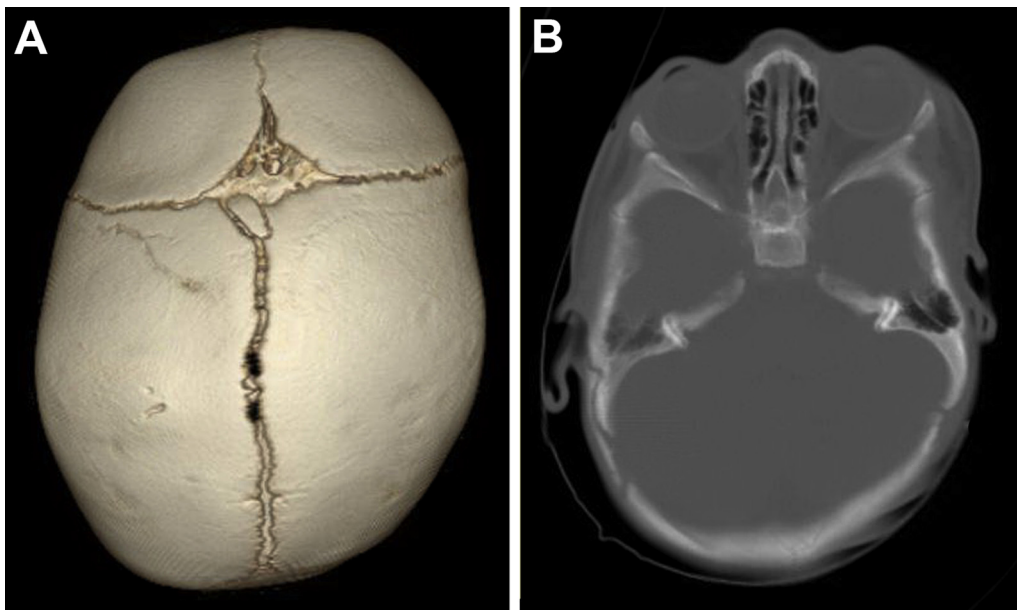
Positional plagiocephaly. Top view (A) of a three-dimensional computed tomography scan (done for other reasons) showing a skull with a parallelogram shape. There is right posterior flattening and anterior displacement of the right forehead. Axial computed tomography scan (B) showing anterior displacement of the ear ipsilateral to the posterior flattening. The sutures are open. (The color version of this figure is available in the online edition.)
